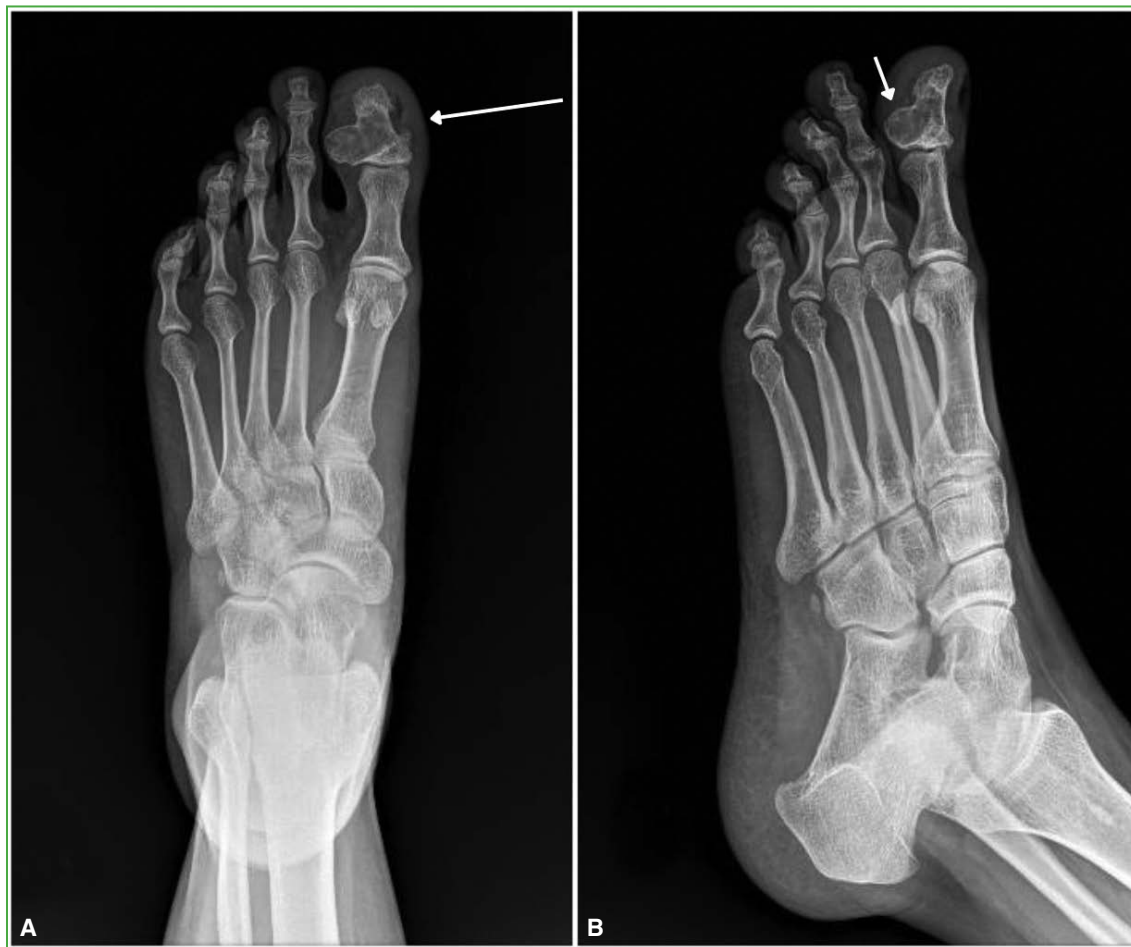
Radiographs of the right foot. A. Anteroposterior view. Eccentric lesion involving the proximal metaphyseal-diaphyseal region of the distal phalanx of the hallux (long arrow). B. Oblique view. Thinning of the dorsolateral cortex (short arrow).
